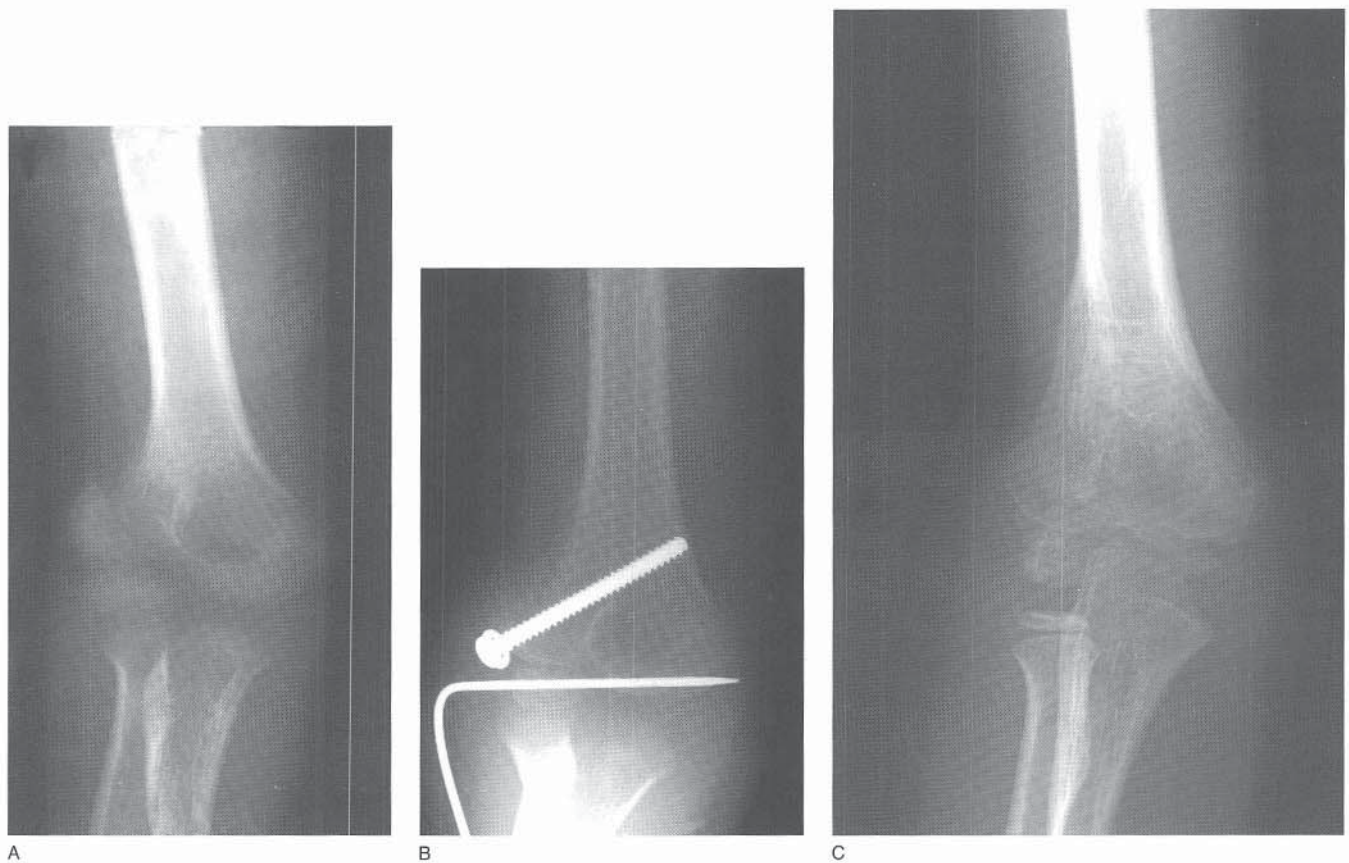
Treatment of a late-presenting lateral condyle fracture. A, AP radiograph obtained at initial presentation, 5 weeks after injury, shows a displaced lateral condyle fracture. B, Open reduction with internal fixation was performed. Note the fracture was not reduced anatomically but was placed in a position to maximize metaphyseal contact. A screw was used through the metaphyseal fragment, as delayed healing was anticipated. A percutaneous pin provided initial rotational stability. C, AP radiograph obtained 18 months after treatment.
